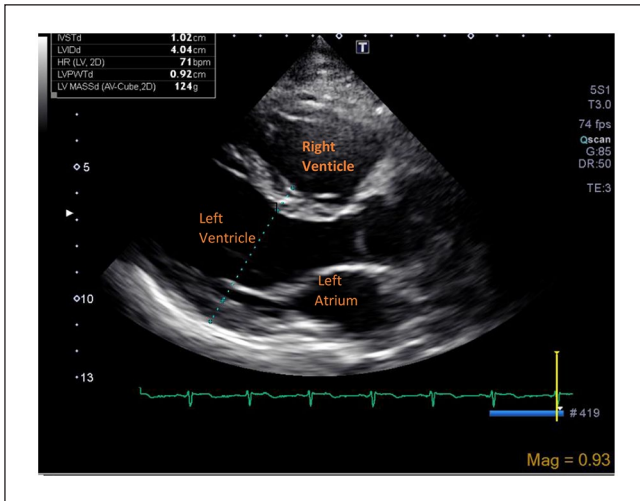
Parasternal long axis view of the transthoracic echocardiogram of the patient performed 8 months prior showing a normal left atrium and ventricle without any mass.
